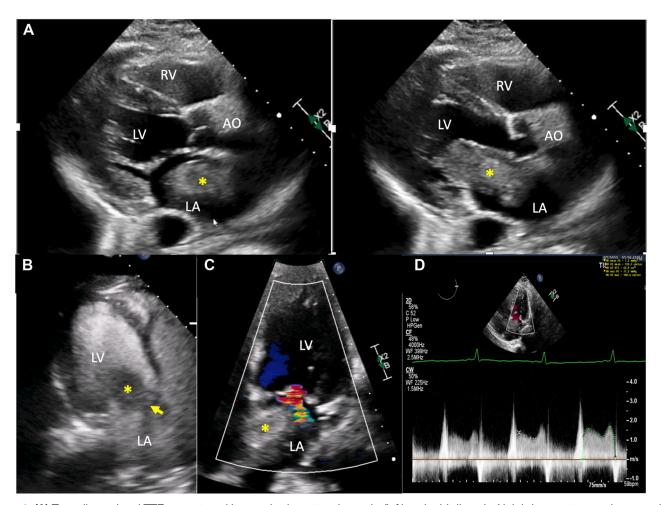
(A) Two-dimensional TTE, parasternal long-axis view at end systole (left) and mid diastole (right) demonstrates a large, mobile, heterogeneous, hyperechoic 5.8 × 2.8 cm mass (*) possibly attached to the interatrial septum protruding into the mitral inflow during diastole (right). (B) Apical 3-chamber view (mid diastole) after the administration of an UEA demonstrates that the mass (*) is partially enhanced (arrow). (C) Apical 4-chamber systolic view with color-flow Doppler (low Nyquist limit) demonstrates the mass (*) and mild MR. (D) Apical 4chamber view with color-flow Doppler-guided continuous-wave spectral Doppler display demonstrates the hemodynamic significance of this large mass with a mean pressure gradient >7.0 mm Hg and calculated mitral valve area <1.0 cm² (velocity time integral method) suggestive of moderate-severe mitral stenosis. Ao, Aortic root; LA, left atrium; LV, left ventricle; RV, right ventricle.
